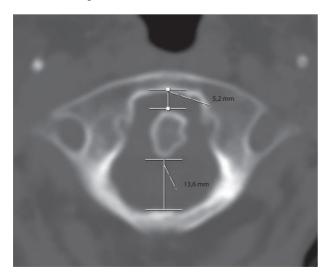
Rheumatoid arthritis – CT Axial CT scan image of the same patient as in Figure 17.39. Measurements of ADI and SAC.
